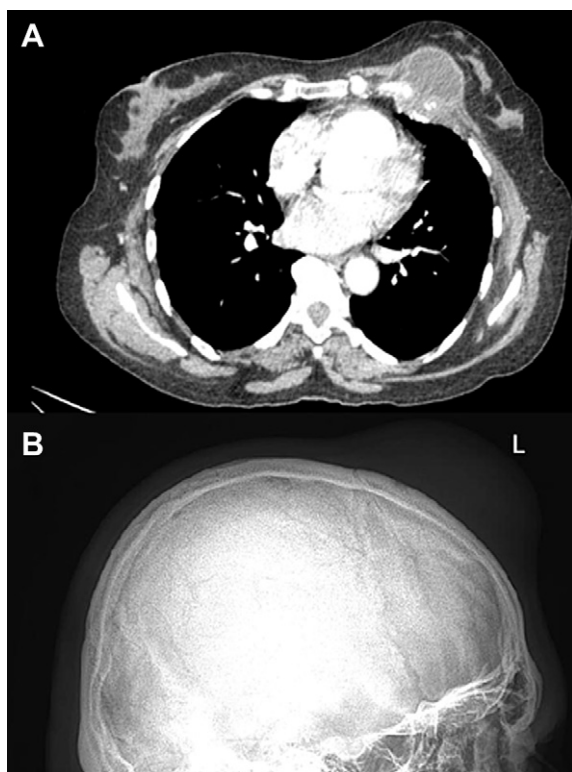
A: Cross sectional Computed Tomography (CT) image from patient 1. A low density lesion in the left parasternal region extending through the chest wall at the 4th rib, and extensive mediastinal lymphadenopathy, is seen. B: Plain lateral skull radiograph from patient 2. A soft tissue density swelling overlying the frontal bone is visible.
